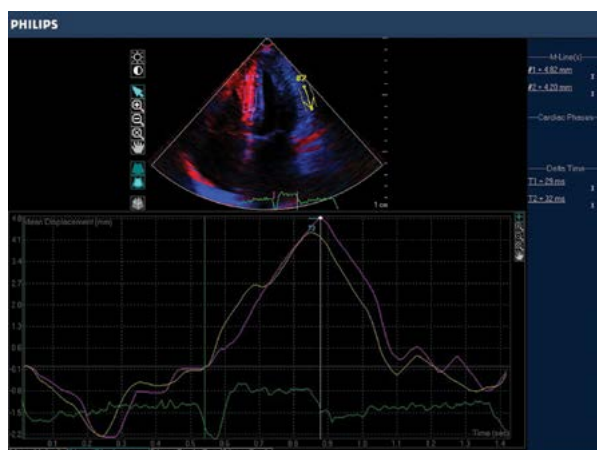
Intraventricular dyssynchrony among patients with RVSP by strain imaging using speckle tracking method showing delay of 32 ms between septal and lateral wall in apical four-chamber view
